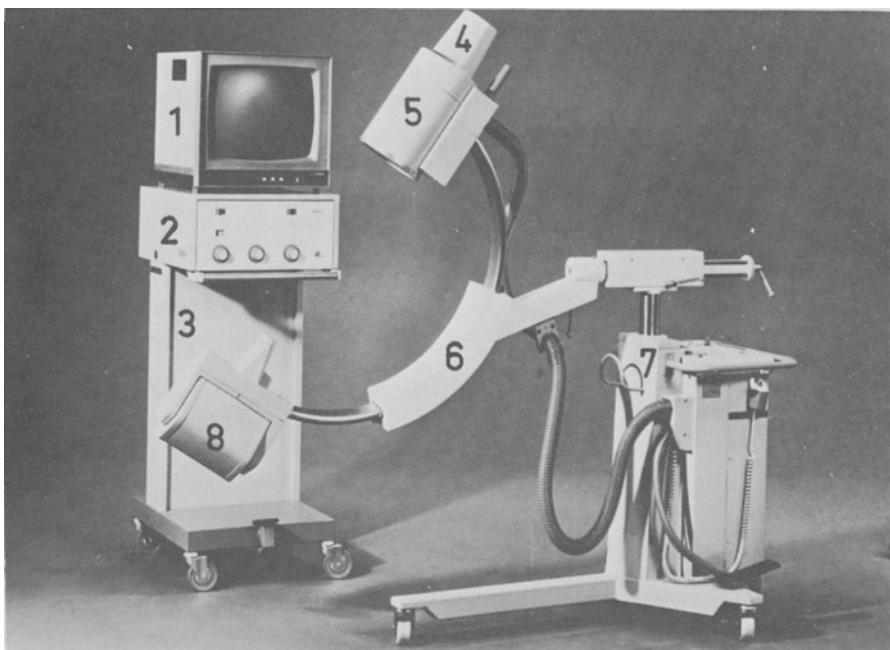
Mobile stand for fluoroscopy with image intensifier and television and radiographic exposures. 1. Television monitor; 2. television controls; 3. mobile frame; 4. television camera; 5. image intensifier; 6. support onto which the C-arm with the X-ray tube and image intensifier are attached and which can be rotated, raised and lowered; 7. control panel and power supply unit for image intensifier; 8. X-ray tube (tank unit).
